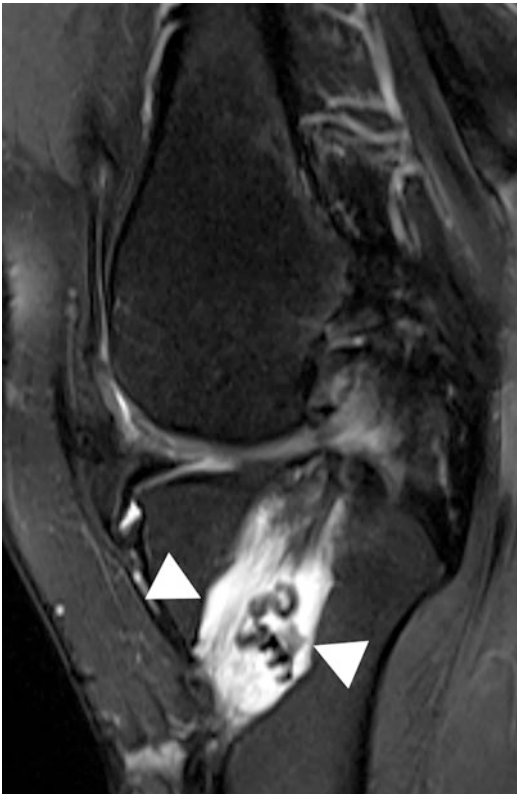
Tunnel osteolysis on MRI after anterior cruciate ligament reconstruction. Sagittal MRI image demonstrates osteolysis of the tibial tunnel, with marked tunnel cystic widening (arrowheads)
